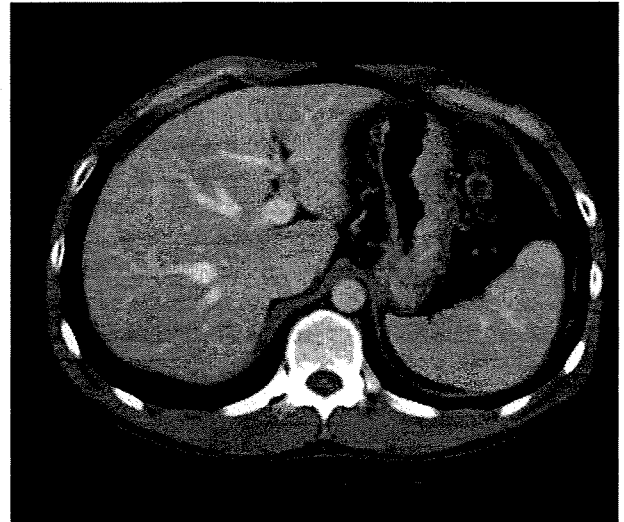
Contrast abdominal CT done three months after embolization. There is no evidence of splenic infarction.
